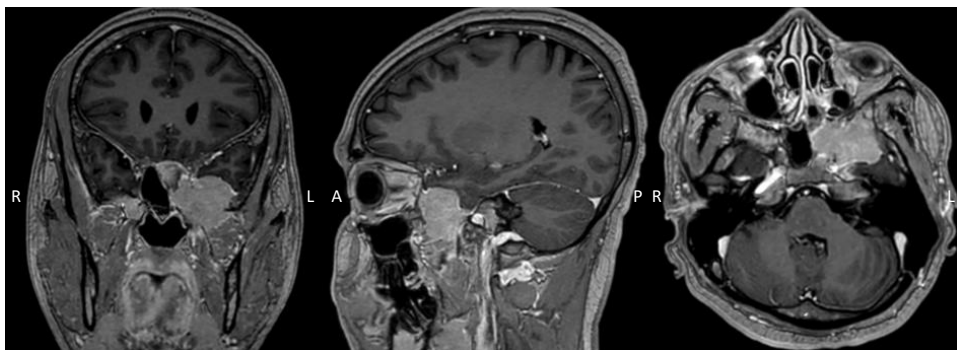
Brain MRI T1-weighted with gadolinium enhancement shows an extra-axial mass centered at the left greater sphenoid wing and pterygoid body, causing intracranial compression of the left temporal pole.
